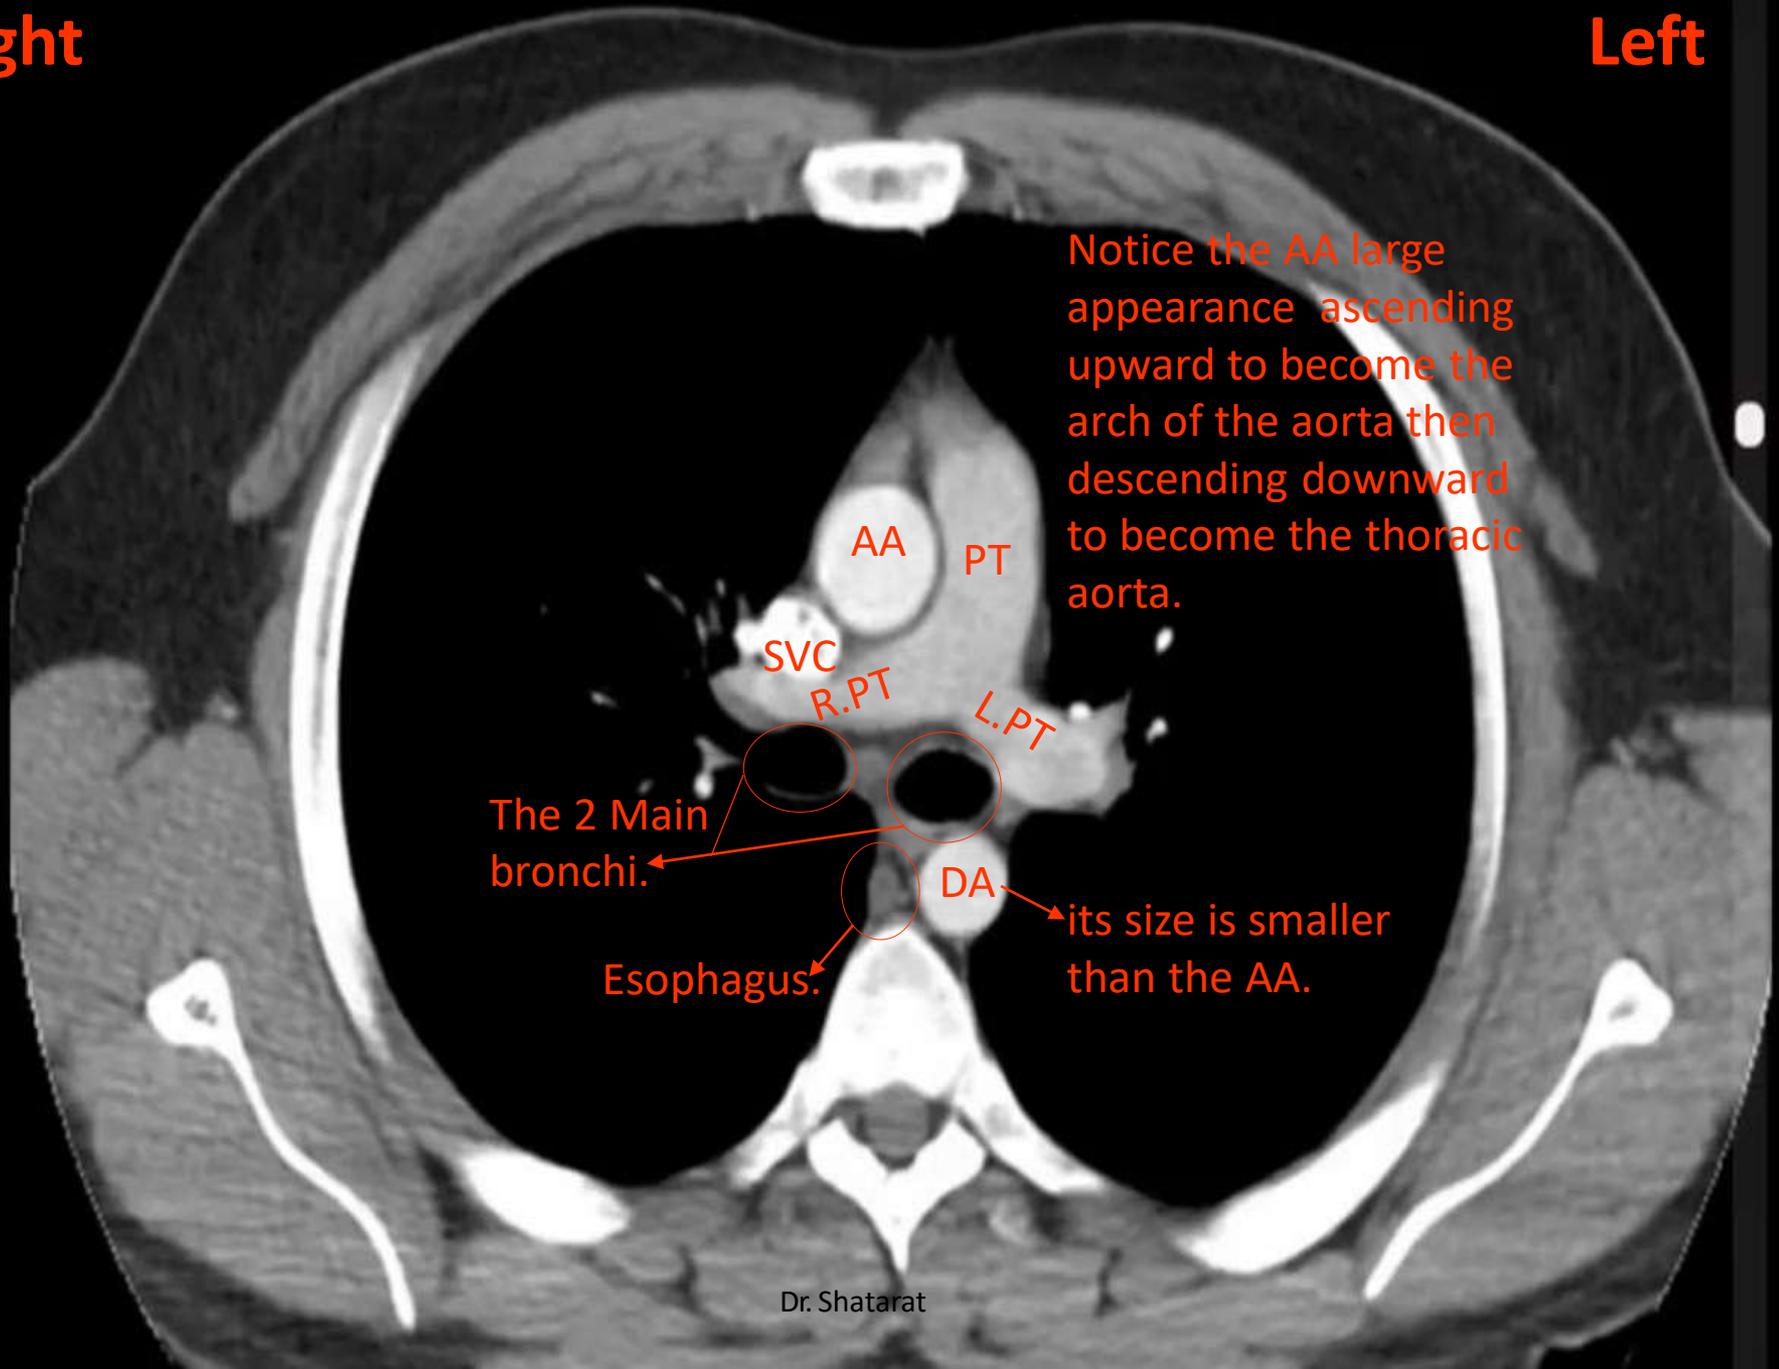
Axial CTA image of the thorax, demonstrates ascending aorta, descending aorta and pulmonary trunk at the upper border of the sixth thoracic vertebra. AA=ascending aorta, DA=descending aorta, PT= pulmonary trunk
